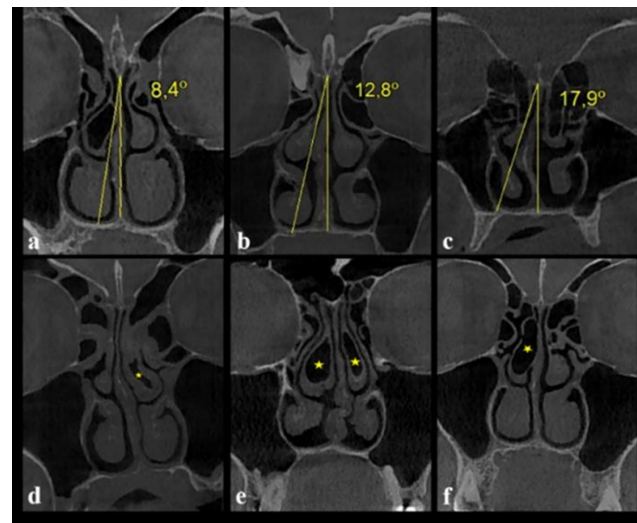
Coronal CBCT images a: Mild nasal septal deviation, b: Moderate nasal septal deviation, c: Severe nasal septal deviation, d: Lamellar concha bullosa, e: Bilateral bulbous concha bullosa f: Extensive concha bullosa
